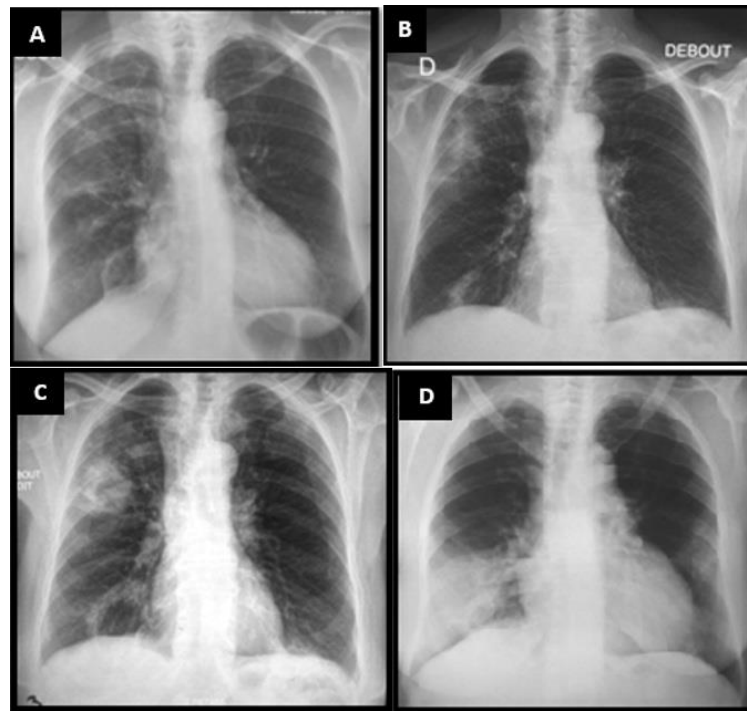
Different radiological patterns of organising pneumonia on chest X-ray: Migrating alveolar opacities (A, B), excavated nodular opacity (C), and invasive alveolar opacity (D)
